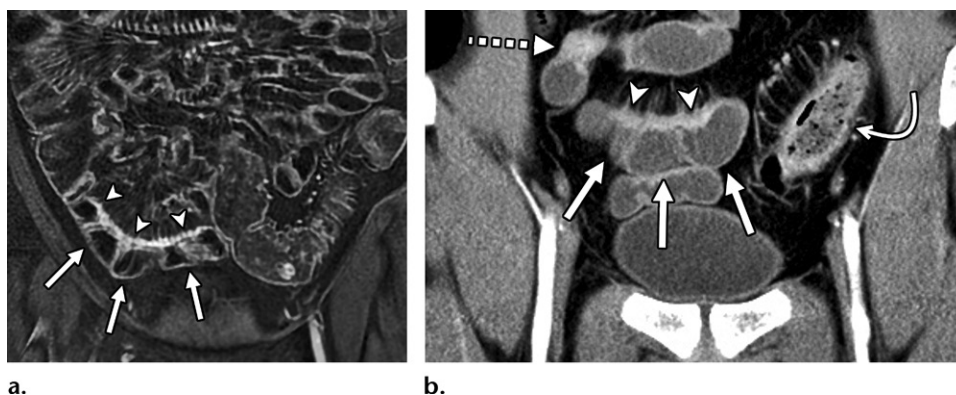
Asymmetric mural hyperenhancement in two patients with Crohn disease. Coronal contrast-enhanced fat-suppressed T1-weighted MR enterographic image with biphasic oral contrast material (a) and coronal contrast-enhanced CT enterographic image with neutral oral contrast material (b) show asymmetric bowel wall thickening and hyperenhancement along the mesenteric side (arrowheads), with relative sparing of the antimesenteric side (solid straight arrows) of the ileum, findings consistent with active inflammation secondary to Crohn disease. As a result, there is effacement of the folds along the mesenteric border and sacculations along the antimesenteric border. Note the engorged vasa recta adjacent to the mesenteric border in both images. The CT image (b) also shows active inflammation with luminal narrowing in a different small bowel loop (dashed arrow in b) and inflammation of the distal colon (curved arrow in b).
